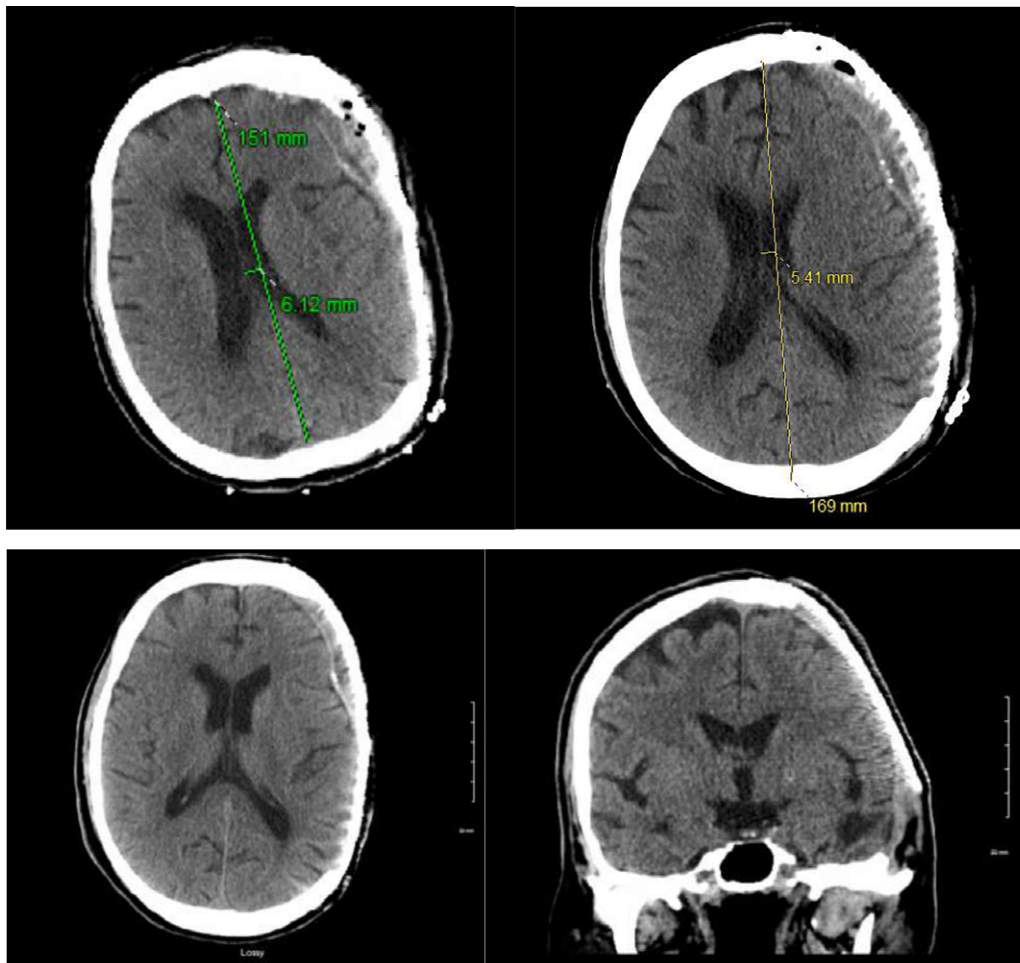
Top: CT non-contrast axial 6 hours (left) and 48 hours (right) post-operatively from an artificial cranioplasty demonstrating resolution of midline shift and sunken skin flap. Bottom: CT non-contrast axial (left) and coronal (right) views 8 weeks post-operatively.
